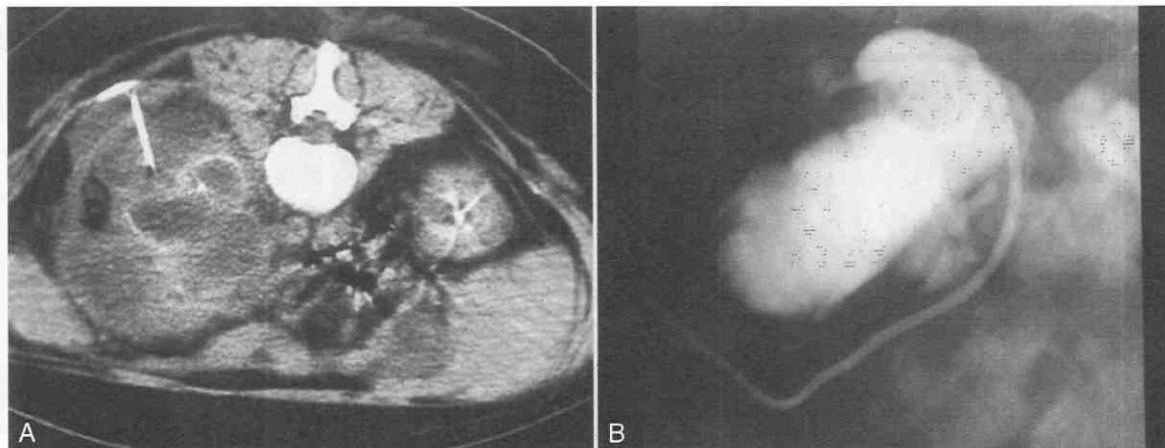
A, CT scan shows a large abscess around the left kidney and severe pyohydronephrosis. The needle trajectory was planned to cross both abscess collections. B, Catheter injection shows opacification of the collecting system and some extravasation of contrast material into the perinephric space.
